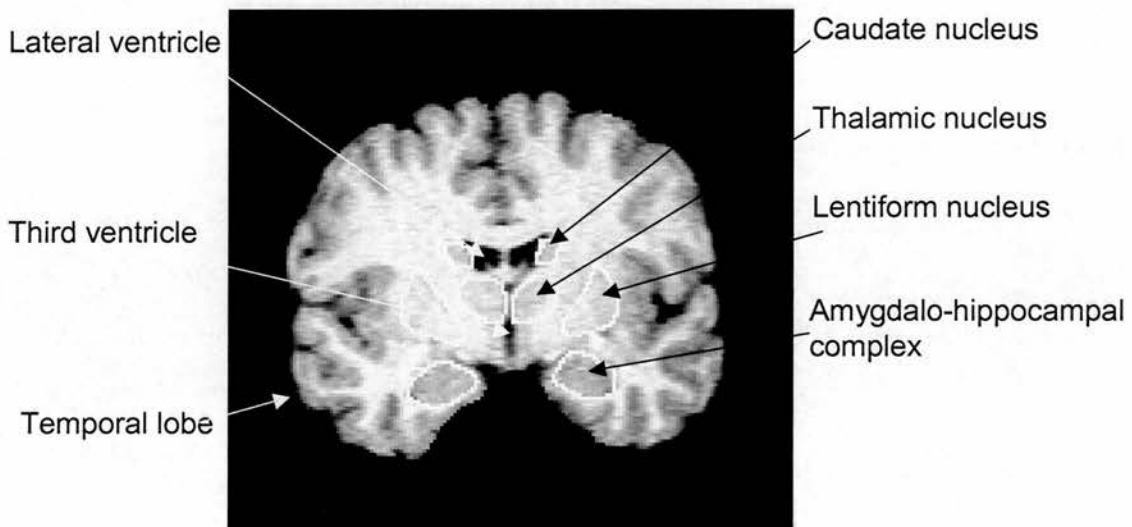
Semi-automated region of interest delineation of structural MR image.
